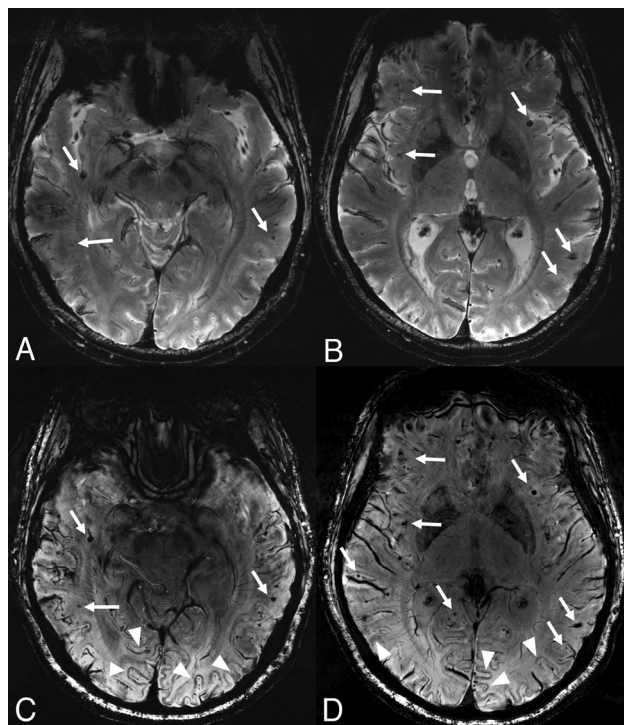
Three-month follow-up 7T MR imaging. Axial T2* images are at the upper row (A and B) and corresponding axial SWI (C and D) are at the lower row. After 3 months, the patient is symptom-free, however, images show an increased number of punctate microhemorrhages in comparison with the corresponding images at previous 7T MR imaging axial T2* (Fig 4A, -B). Arrows point out some of the peripheral microhemorrhages and compared with T2* (A and B), SWI provides a clearer and sharper visualization of some of these microhemorrhages (C and D). In closer look, the entire cortex shows a gyriform susceptibility artifact in certain regions on SWI, most significant in the occipital lobes, which is not technically a superficial pial siderosis but actually corresponds to newly described intragyral hemorrhage sign (arrowheads in C and D). This observation was not well appreciated on T2*.
